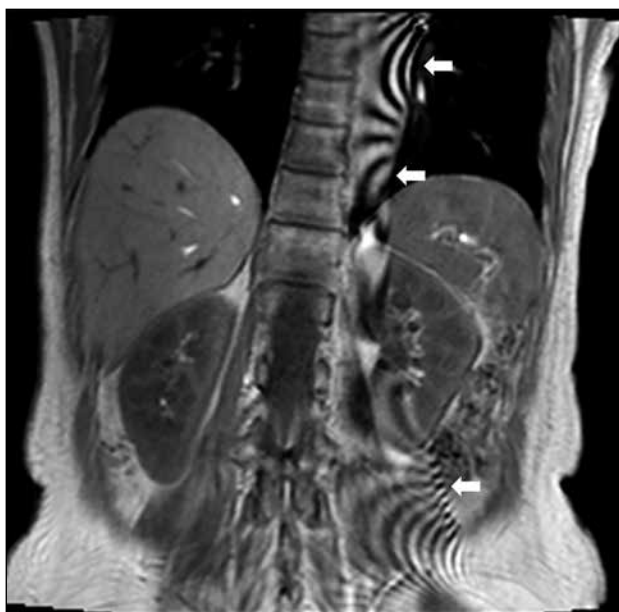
Coronal T1-weighted gradient echo image of the abdomen demonstrates the Moiré fringes or zebra artifacts (white arrows). This artifact is caused by a combination of aliasing and magnetic field inhomogeneity.
